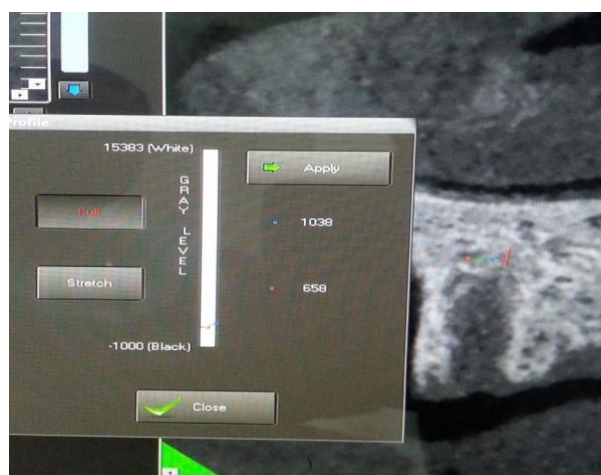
Bone density in periapical region
